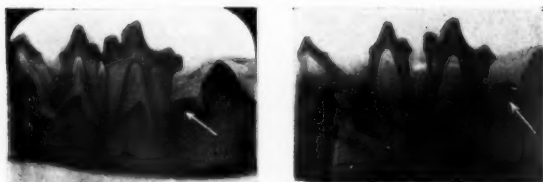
a. Roentgenograms of the mandible bone from Eva, to the left, and Grete, to the right. The thickness of the calcified enamel-dentin cap on the tubercle indicated by the arrow (permanent tooth) is for Eva 1,5 mm and for Grete 2,0 mm.
